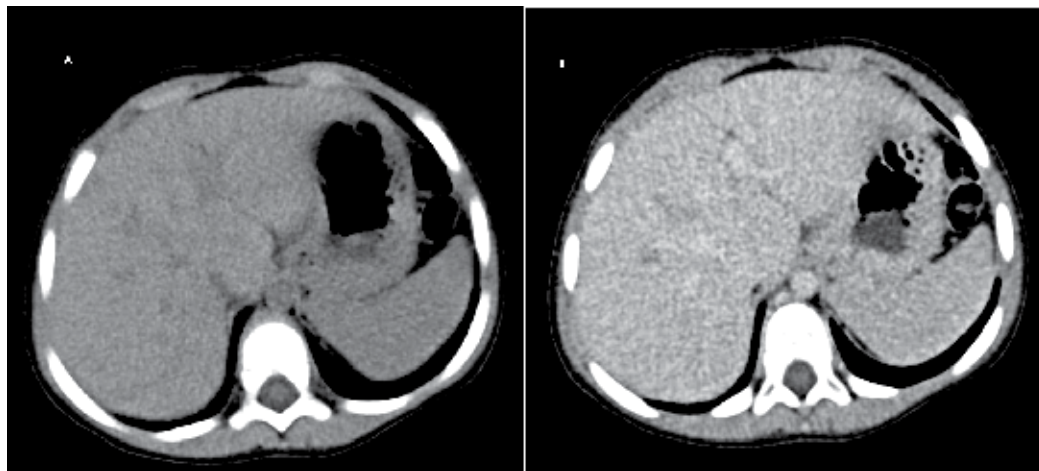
Computed tomography with multiple focal lesions in the liver (A) of lower density than the liver parenchyma after contrast-enhancement (B) corresponding to hemangiomas.
